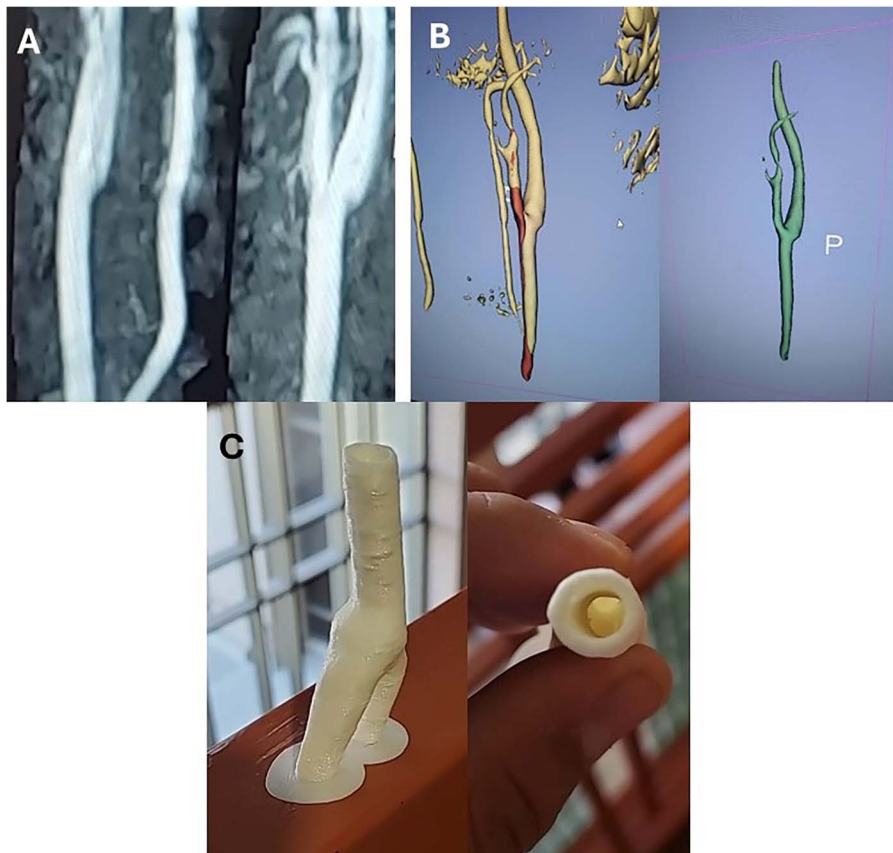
Carotid artery 3D printing process. A, Noncontrast MRI of a human carotid artery; B) images are transferred to imaging processing software (P = posterior); C) carotid artery printed in poly(lactic acid) (PLA) from a traditional 3D printer.
